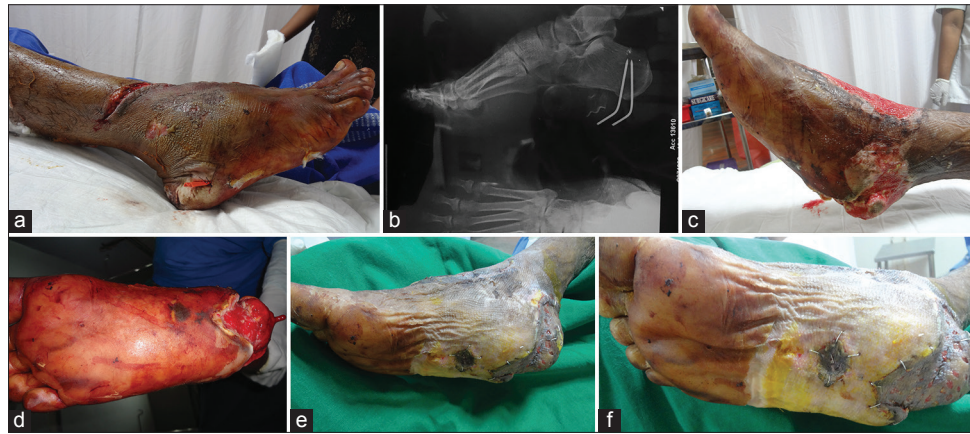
(a) Crush injury right leg and foot with heel pad avulsed skin and subcutaneous tissue connectivity in the proximal and distal part; (b) X-ray lateral view right foot showing K-wires used for stabilization of avulsed heel pad; (c) appearance of foot 3 weeks following debridement and hyperbaric oxygen treatment session; (d) plantar view of foot following 3 weeks; (e) medial view of the foot following skin grafting; (f) plantar view of the foot following skin grafting
